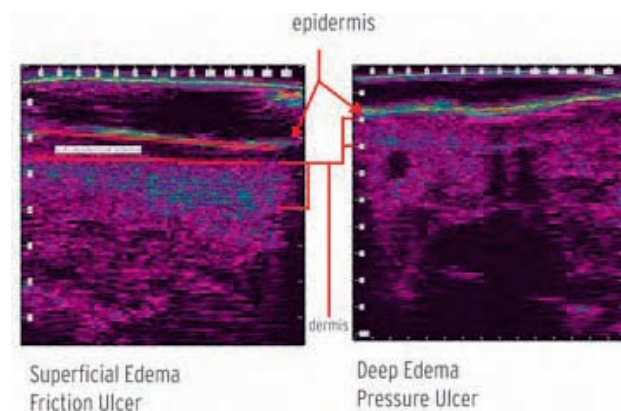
Example of bedside high frequency ultrasound image.
